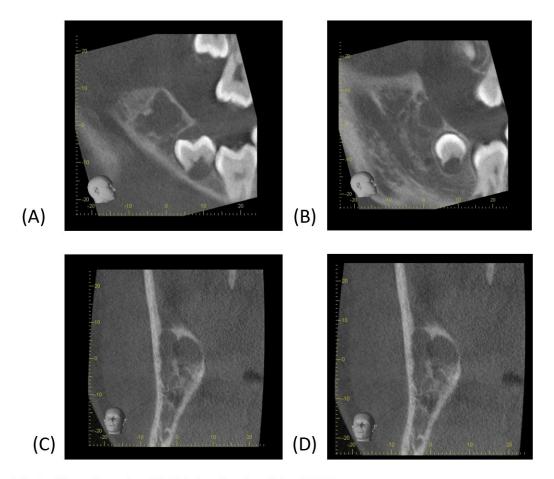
Slices from the CBCT showing the right CGCG
